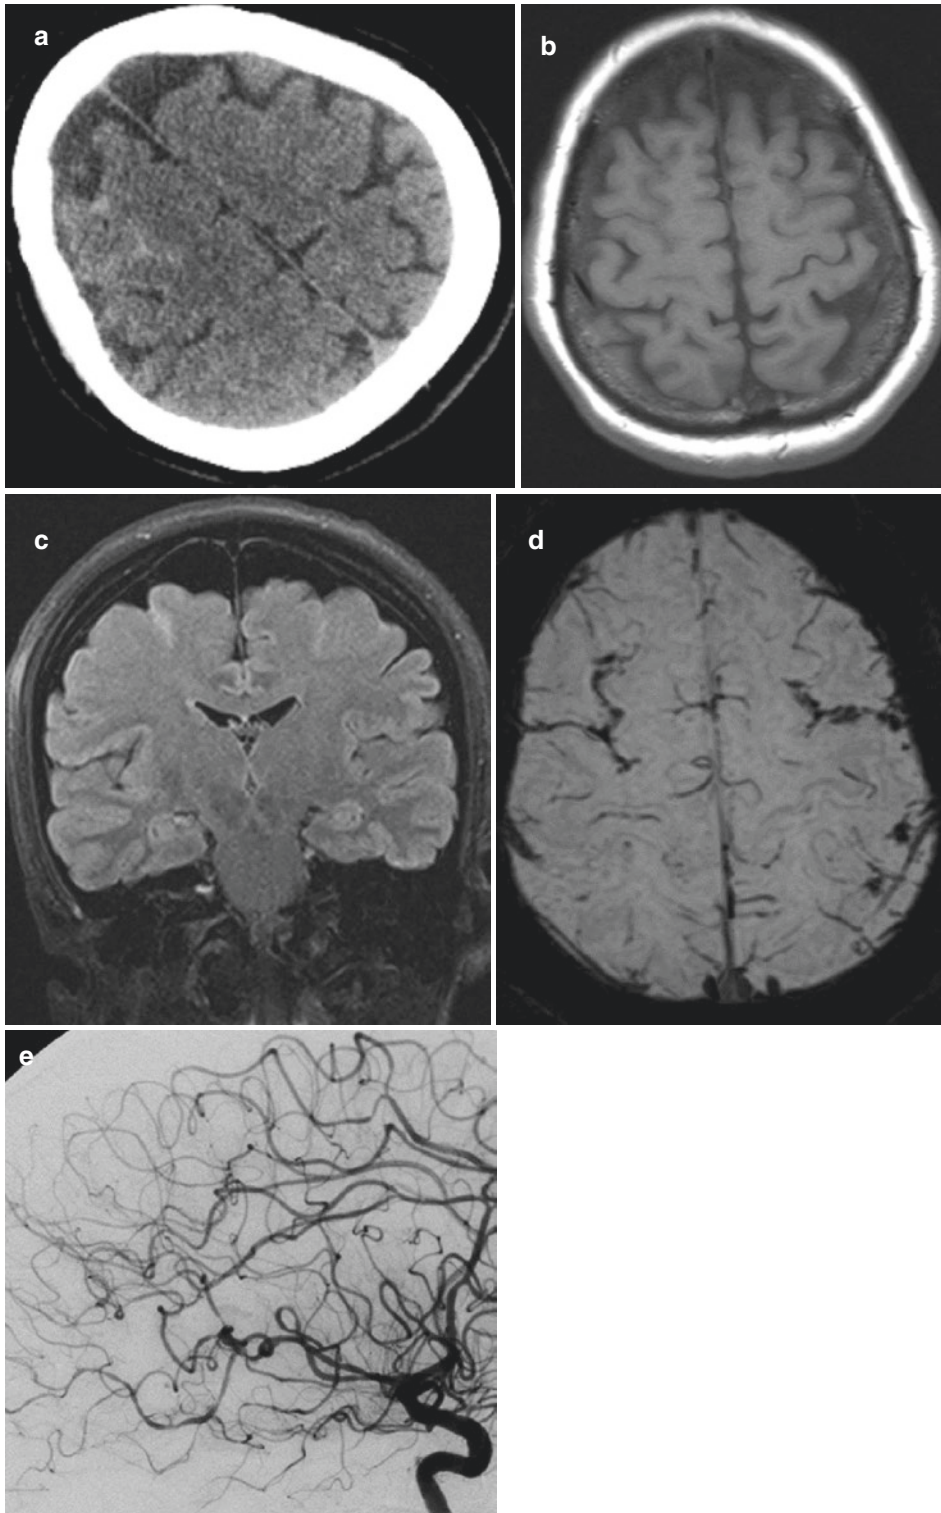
RCVS. (a) Noncontrast CT shows right frontal sulcal SAH in a young woman. T1W image looks normal (b) whereas FLAIR image (c) demonstrates sulcal hyperintensity on the right frontal region. (d) SWI much better
